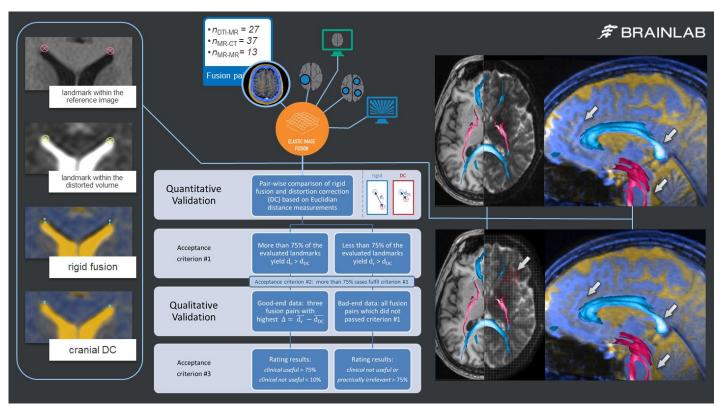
Validation pathway based on clinically representative patient data inlcuding different DTI-MR, MR-CT and high-to-low field MRI fusion pairs. The quantitative evalution is based on Euclidian distance measurements (left) and showed significant improvements (as reported below). The qualitative pathway confirmed that the spyglass (axial images) and blending verification tool (sagittal images) provided by the Elements Cranial Distortion Correction* allow reliable localization and evaluation of fusion-induced image deformations. The application is also capable of automatically correcting fiber tracts as well as segmented objects.
